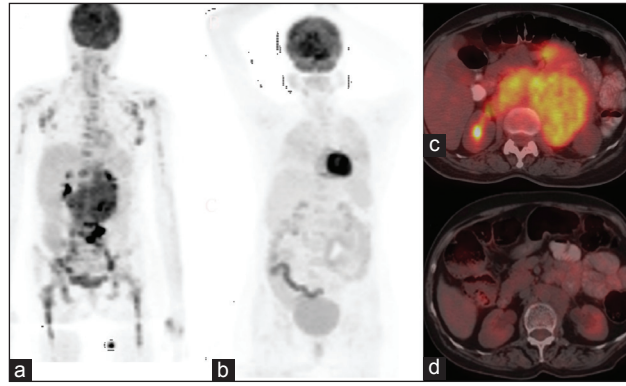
Maximum intensity projection (MIP) image (a) of a patient with diffuse large B cell lymphoma at staging positron emission tomography/computed tomography shows extensive marrow involvement, bilateral axillary lymph nodal and retroperitoneal lymph nodal involvement. MIP image (b) of the same patient after six cycles of chemotherapy showing no abnormal fluoro-deoxy-glucose (FDG) up-take anywhere in the body. Transaxial images of pre-therapy and post therapy scans respectively (c and d) show residual mass of size of 4.4 cm × 2.2 cm in the retro-peritoneum. However no increased FDG uptake is noted in the mass (equal to background) and according to International Harmonization Project criteria persistent mass of any size with negative FDG uptake should be categorized as complete response. Accordingly this patient was classified as complete responder and was disease free on follow-up of 2 years
